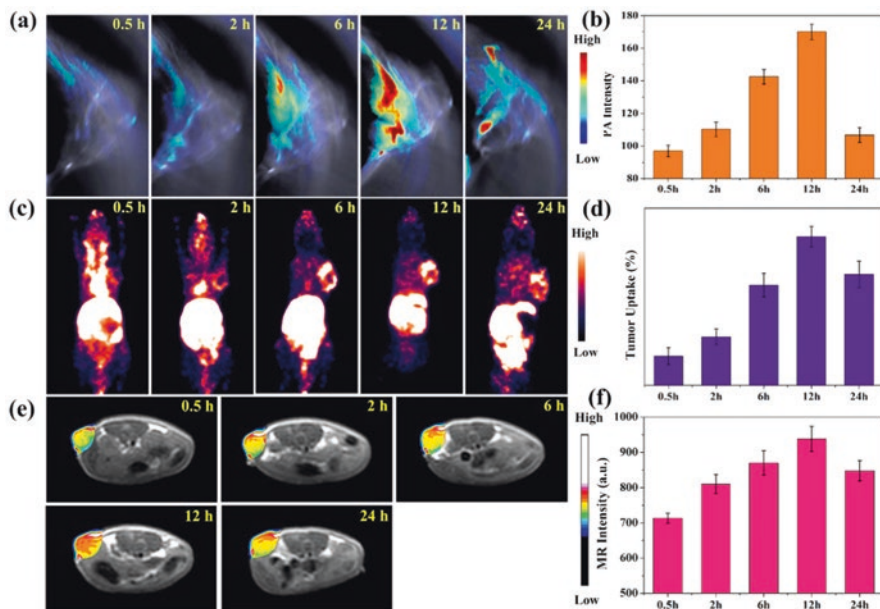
Representative images of in vivo (a) PAI and (b) its quantitative estimation, (c) PET imaging, (d) tumor uptake of GNR@MNPs-Gd-⁶⁴Cu, (e) MRI, and (f) its quantitative estimation. (Image adapted from Ref. [57])
